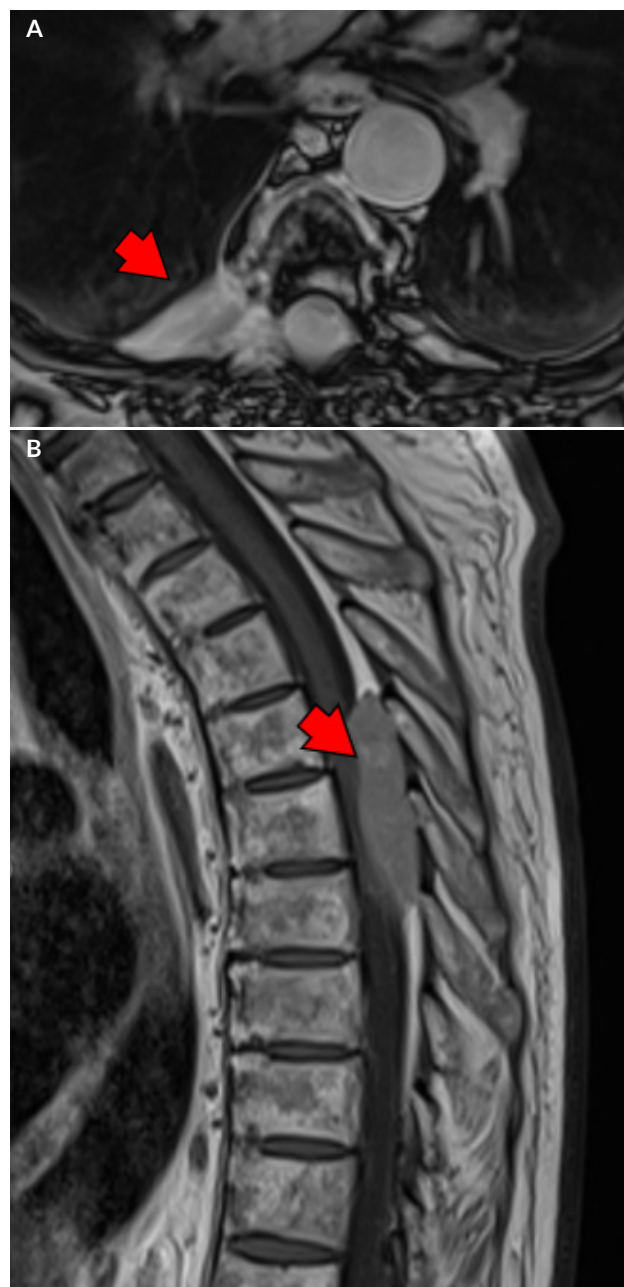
MRI scan of head and spinal cord revealed T6 posterior paravertebral mass extending into the spinal canal.
